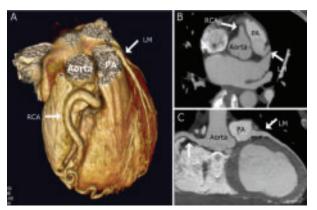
CT angiogram of ALCAPA
